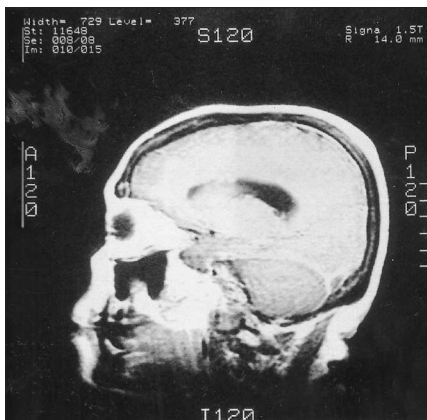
Enhanced T1-weighted sagittal image showing a filling defect at the confluence of the sinuses.
